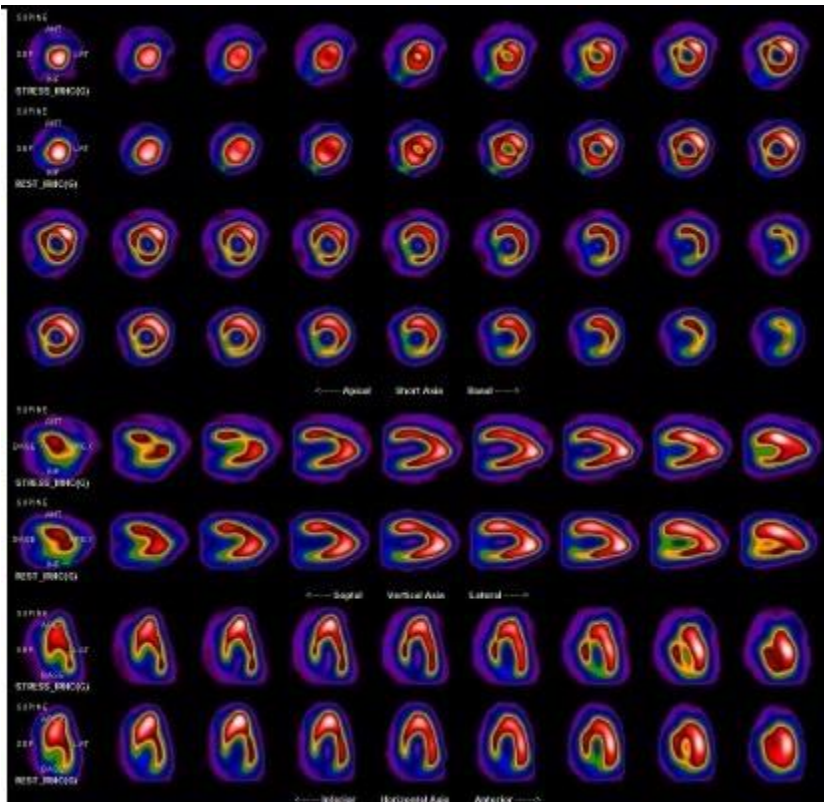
Stress/rest myocardial perfusion SPECT of a patient with suspected coronary artery disease
